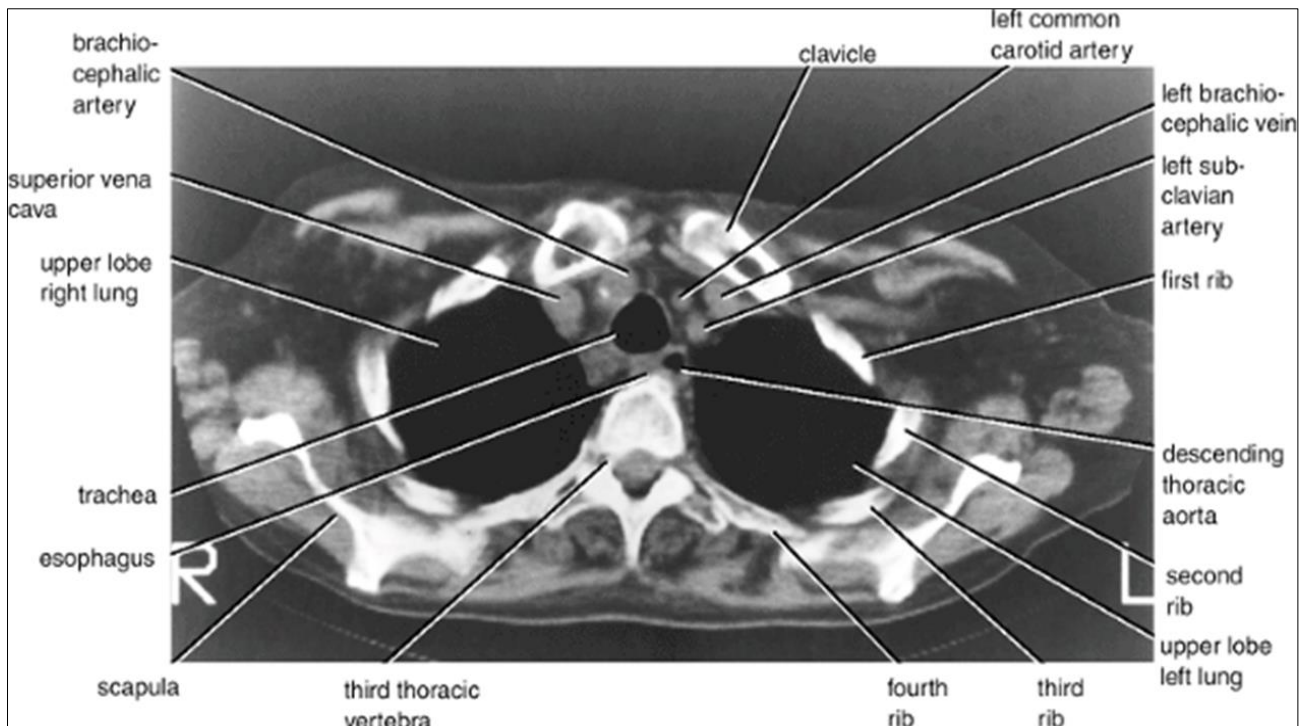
CT scan of the thorax at the level of the third thoracic vertebra. *Courtesy; Keith Moore & Arthur Dalley*
